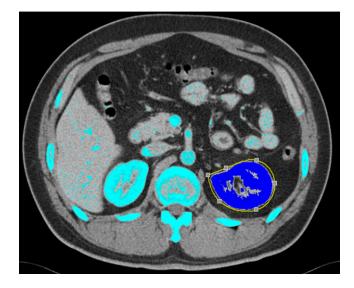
CT shows kidney volume calculated based on normally functioning tissue (dark blue areas). Nonenhanced areas were excluded using software.
